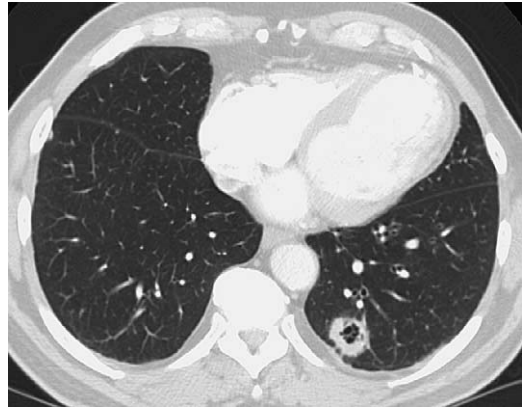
A 73-year-old man with metastatic adenocarcinoma. CT scan showed multiple pulmonary nodules that were cavitary.
